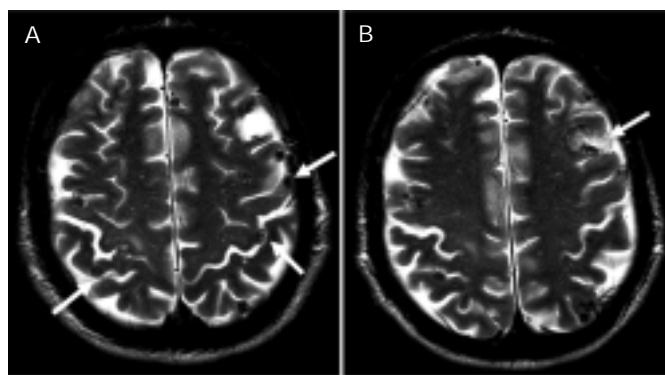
Admission brain MRI shows on T2 weighted images. A. Multiple calcifications in frontal motor strip (arrows). B. Cysticercus in granular stage in left frontal lobe (arrow).
